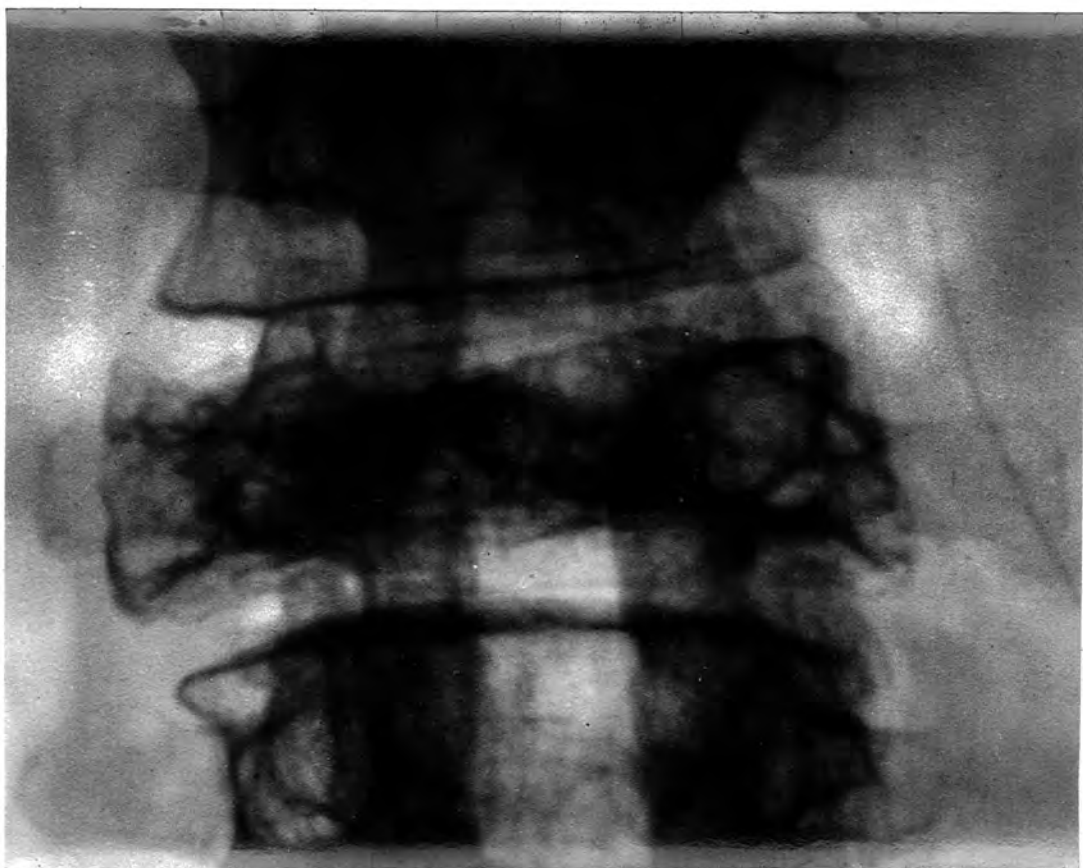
CASE TWENTY-THREE. X-ray of lumbar spine, lateral view, taken 6 years after first symptom. L.3 is collapsed and sclerosed; local recurrence had not taken place.
